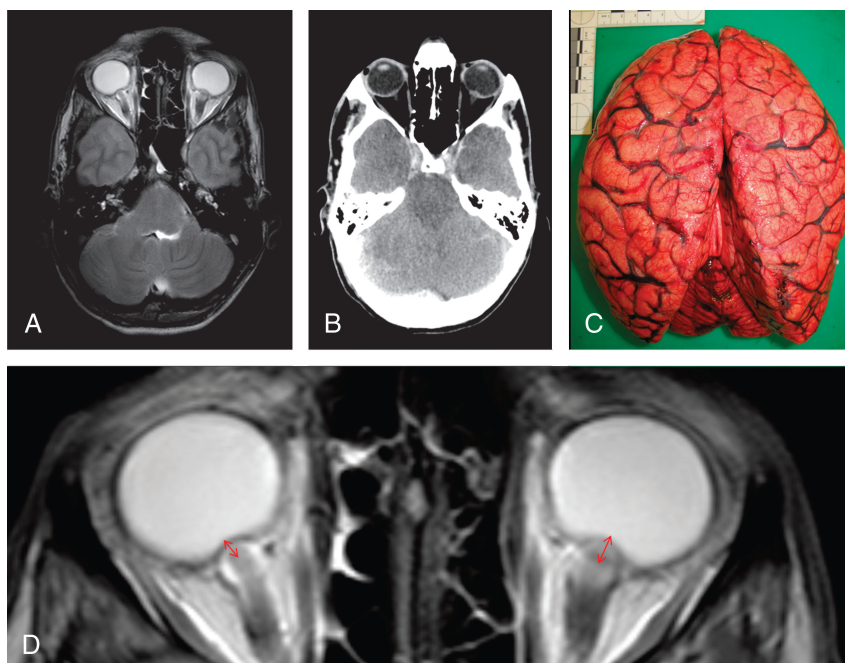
This case exhibits extensive brain edema as detected on PMMR and autopsy. The brain weight was 1540 g for this 27-year-old man who died of central regulatory failure due to a ruptured cerebral aneurysm. A, T2-weighted PMMR sequence showing the extensive PA. B, Postmortem computed tomography for comparison with A. Note the hypodense cerebral tissue with the loss of the white and gray matter differentiation as well as the PA, which is not as distinct as it is on PMMR (A). C, Autopsy photograph of the brain showing flattened gyri and sulci and a soft consistency of the brain that is indicative of cerebral edema. D, Magnified view of the PA (indicated by the red arrows) shown in A with clear edemas located at the papillae of both eyes. Note the fluid along the optic nerve sheath.
